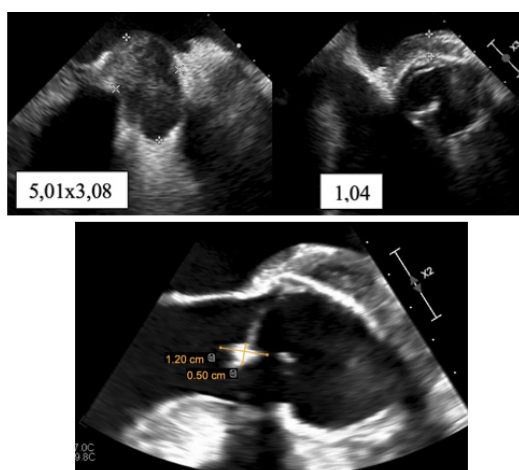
Echocardiographic features of aortic root abscess with vegetation on the right coronary cusp
